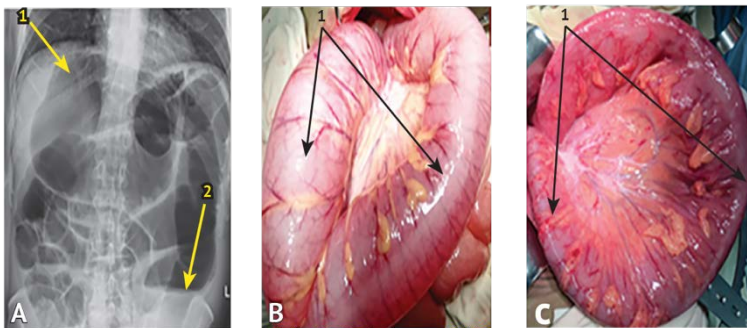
Repeated admission. A — plain X-ray image of the abdominal cavity. A dramatically swollen loop of the sigmoid colon (arrow 1) with a fluid level (arrow 2) are revealed; B — intraoperative photo of volvulus of the sigmoid colon before decompression (arrow 1 — enlarged sigmoid colon); C — Intraoperative photo of volvulus of the sigmoid colon after melting and decompression (arrow 1 — intubated sigmoid colon)
